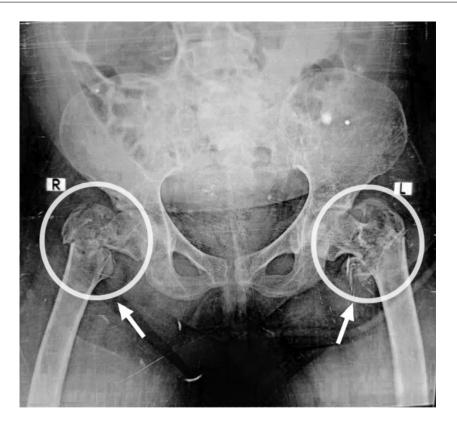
Radiograph showing bilateral fracture of neck of femur.
